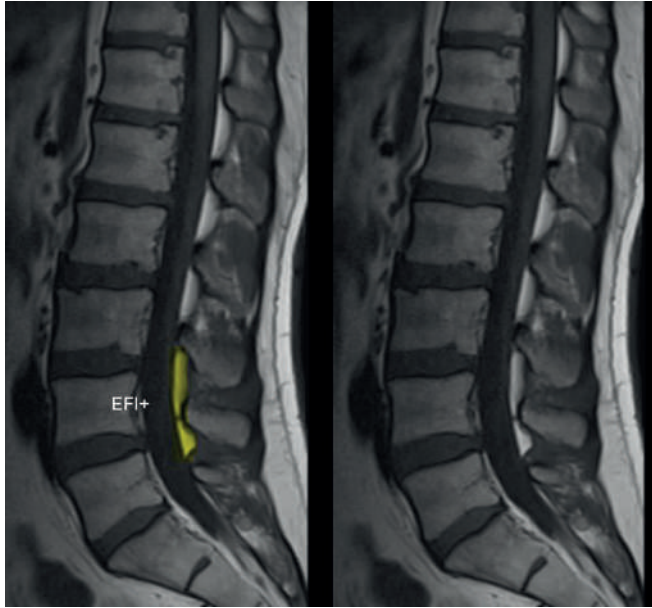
In mid-sagittal T1-weighted images, impaired posterior epidural fat segmentation and epidural fat interposition (EFI) are established indirect radiological markers of spondylolysis with high diagnostic reliability.
